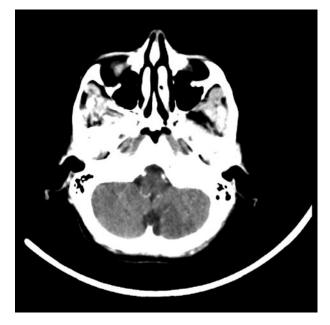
Axial computed tomography head scan demonstrating a wedge opacity of the medial left cerebellar lobe.
